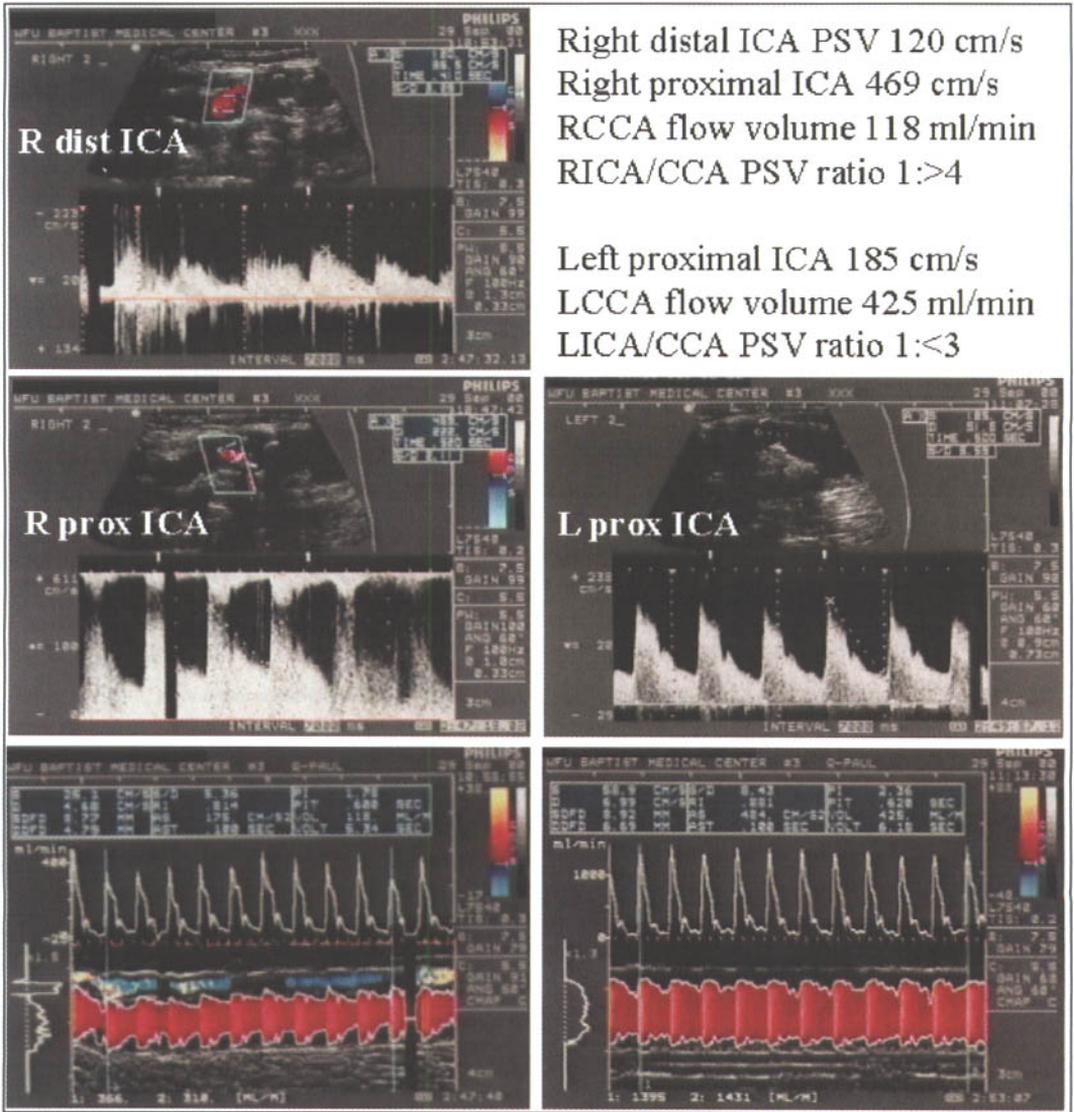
An 86-year-old white male with hypertension, coronary artery disease, carotid stenosis and hypothyroidism was evaluated for syncope following a blackout episode. Carotid duplex ultrasound showed a severe stenosis (75–95%) in the right internal carotid artery (ICA). (a) Carotid color duplex ultrasound study with very high velocities (469 cm/s systolic, 222 cm/s diastolic) at the point of aliasing at the exit of the right ICA stenosis. The following steps can be used to further optimize, or ‘clean up’ the recording: (i) balance transducer position with patient breathing to achieve a steady intensity of the Doppler spectrum; (ii) use a small (< 1.5 mm) gate to focus on the jet exiting the stenosis and to avoid spectral broadening; and (iii) replay the Doppler signal to select a representative sweep with the highest systolic and diastolic frequencies. (b) A color flow jet and Doppler spectrum
